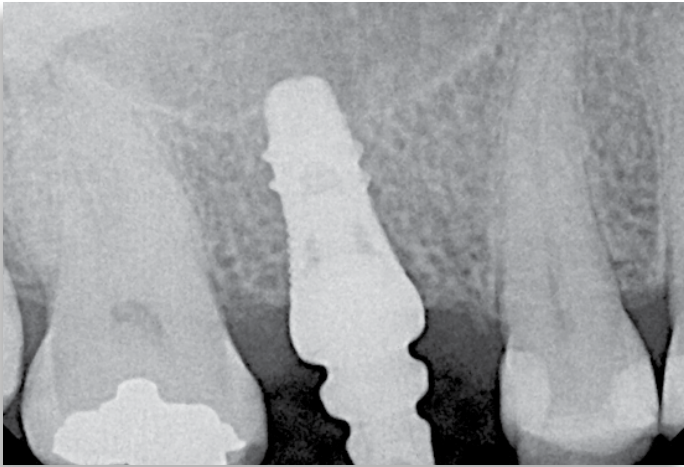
A radiograph is taken to ensure a complete seat of the impression coping. This is a mandatory protocol procedure to ensure the impression coping engages the implant completely.
